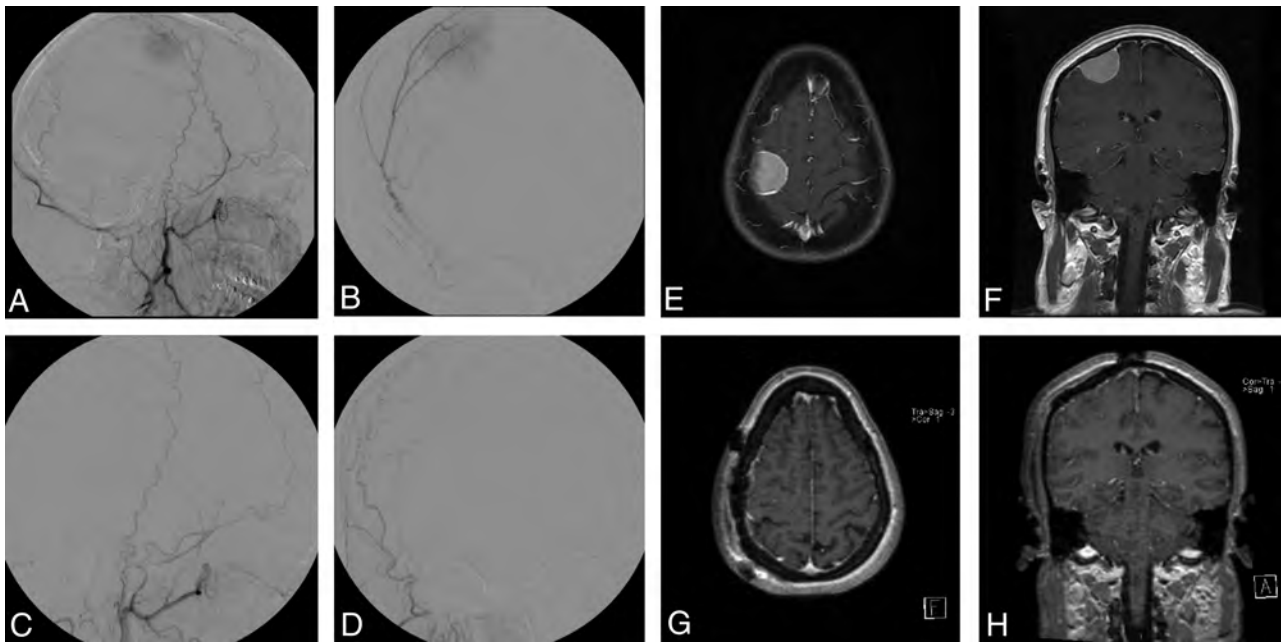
Right frontal meningioma, pre- and postembolization and resection. Pre-embolization right ECA injection demonstrates tumor blush from the middle meningeal artery (A, lateral view; B, frontal view). Embolization was achieved with 150- to 250- μ m PVA particles. Postembolization right ECA injection reveals complete obliteration of tumor blush (C, lateral view; D, frontal view). T1-weighted MR imaging with gadolinium before embolization (E, axial view; F, coronal view). T1-weighted MR imaging with gadolinium postresection (G, axial view; H, coronal view).
